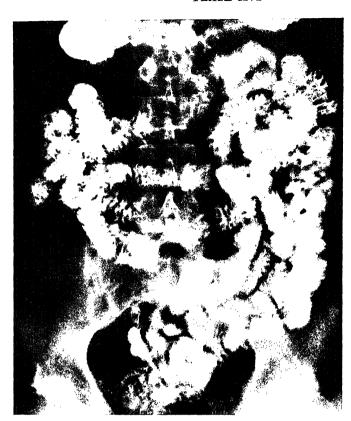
Radiograph of the small intestine after a barium meal. The 'feathery' appearance is due to the presence of the circular folds in the mucous cont.
